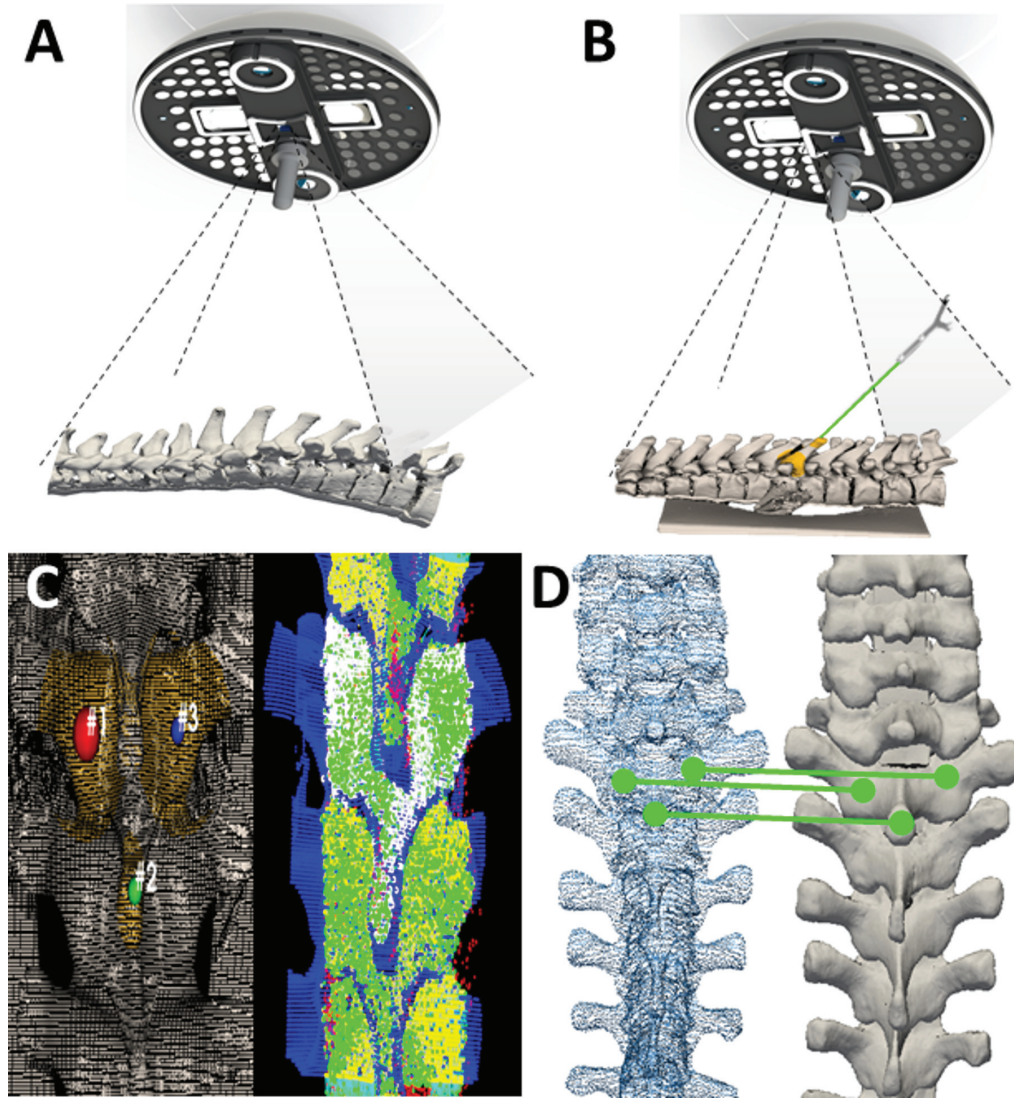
Conceptual design of optical topographical imaging (OTI) experimental navigation system. A) Structured light patterns projected into the open surgical field. Structured light patterns deflect and deform upon reaching the surface of the target. Pattern deformations reflect height variations (along the optical axis) of the surface. B) Registered reconstructed surface data to pre-acquired imaging data with tool tracking capabilities. Verification of the system's accuracy is conducted by sliding a passively tracked probe along bony landmarks of the anatomy and confirming the system is reporting the tool's spatial location correctly. C) Registration of the acquired 3D-point cloud to pre-acquired imaging data (i.e. CT, MRI, OTI) using an iterative closest point (ICP) algorithm based on a three-point picking protocol. D) Grey-scale stereoscopic cameras acquire topographical images. Images are captured as the light patterns are projected onto the surface. 3D reconstructed and thresholded point-cloud representing the bony surface of the spine.
